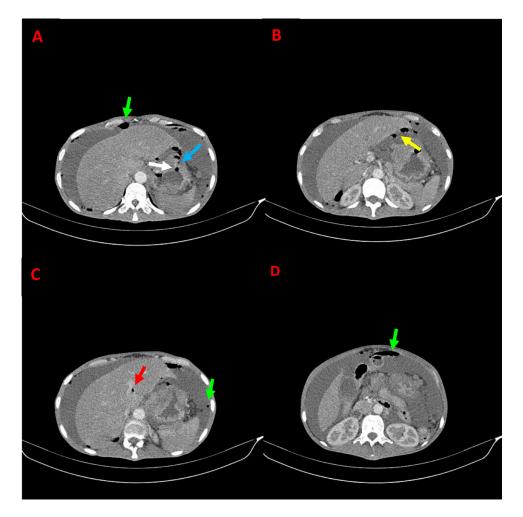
Axial CT scan images showing focal wall defect at the gastric body (blue arrow) with a small amount of air around the perforation site (white arrow), in theomental bursa (yellow arrow), at the fissure of the ligamentum teres (red arrow) and in the peritoneum (green arrows). Color version of figure is available online.
